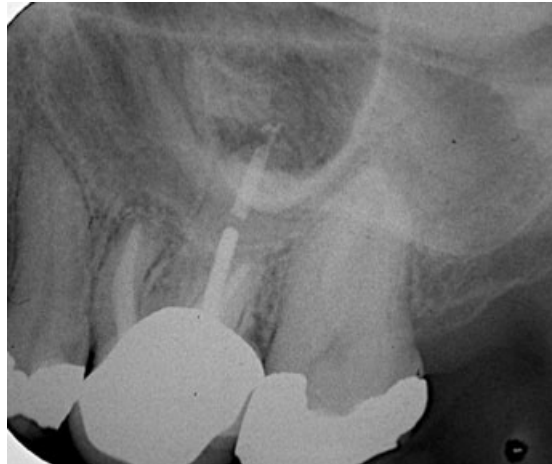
Periapical radiograph showing tooth 26 at the 6-month recall evaluation after the retreatment.
